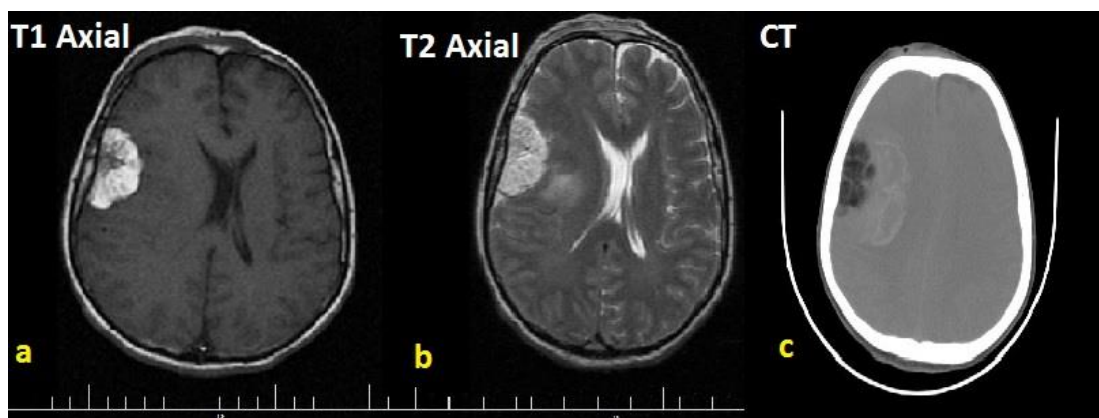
(a) T1 (b) T2 weighted MRI axial image showing hyperintense left temporoparietal extra axial broad based mass (straight arrow) with a dural tail. (c) Axial CT scan reveals a hypodense left temporo-parietal mass (arrow) with Hounsfield units indicating lipomatous tissue.
